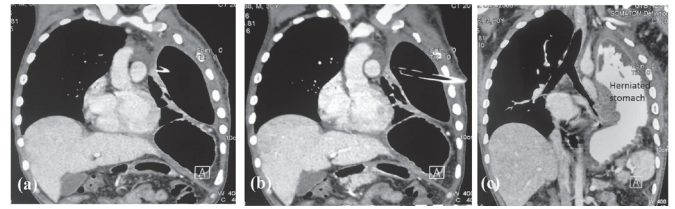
(a-c) Coronal sections of computed tomography of chest and abdomen.
